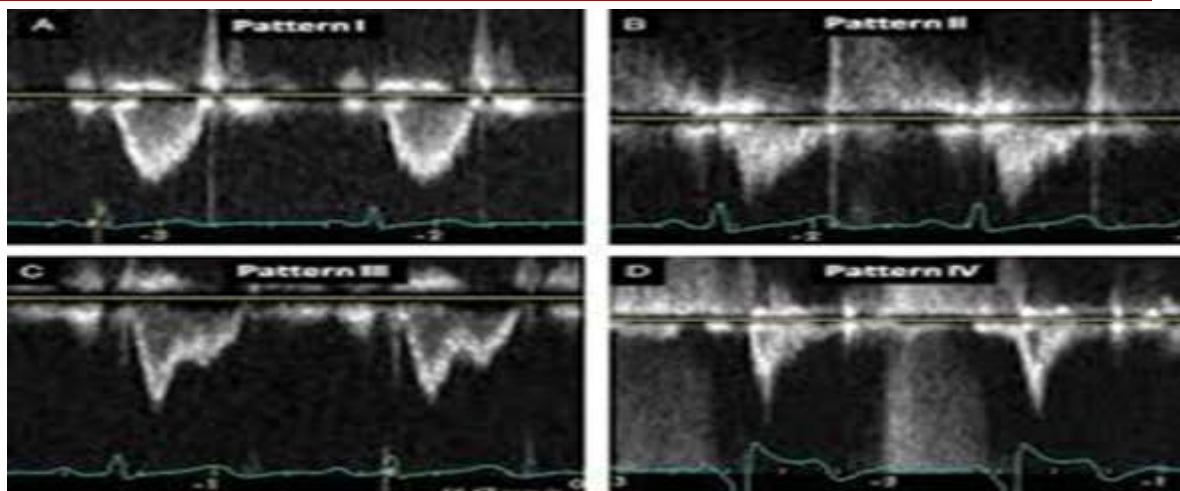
Visual inspection of RVOT envelop shapes by pulsed doppler
